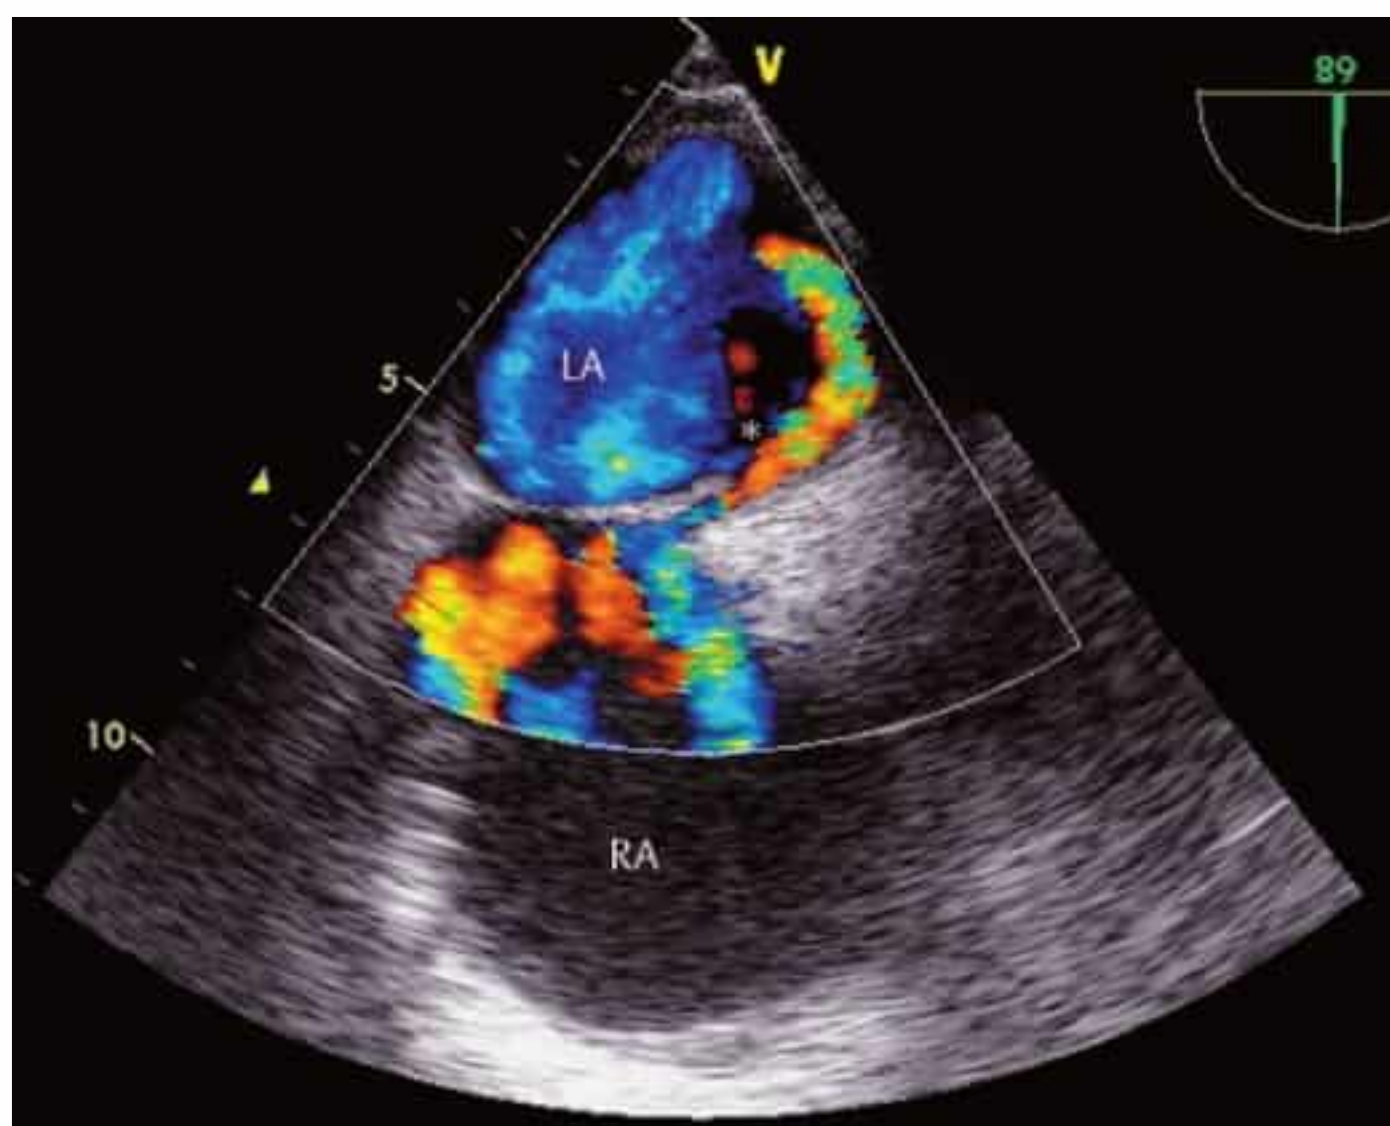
Detection of PFO by transesophageal color Doppler echocardiography, with demonstration of flow through the deflected septum secundum (asterisk).
